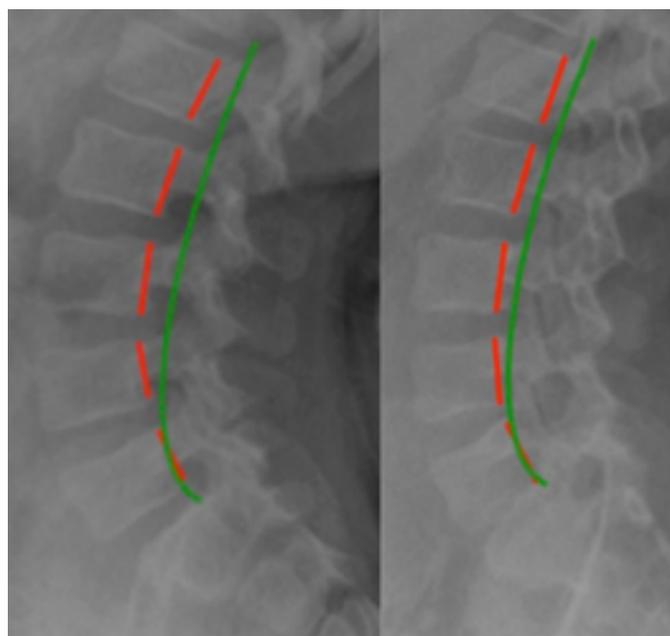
Lateral lumbar radiographs. Left: Pre shows lumbar hyperlordosis L1-L5 ARA of -54°. Right: Post shows reduction to -46.1°. Note: Red line indicates posterior vertebral body margins; green line indicates normal (CBP Seminars, Inc.).
